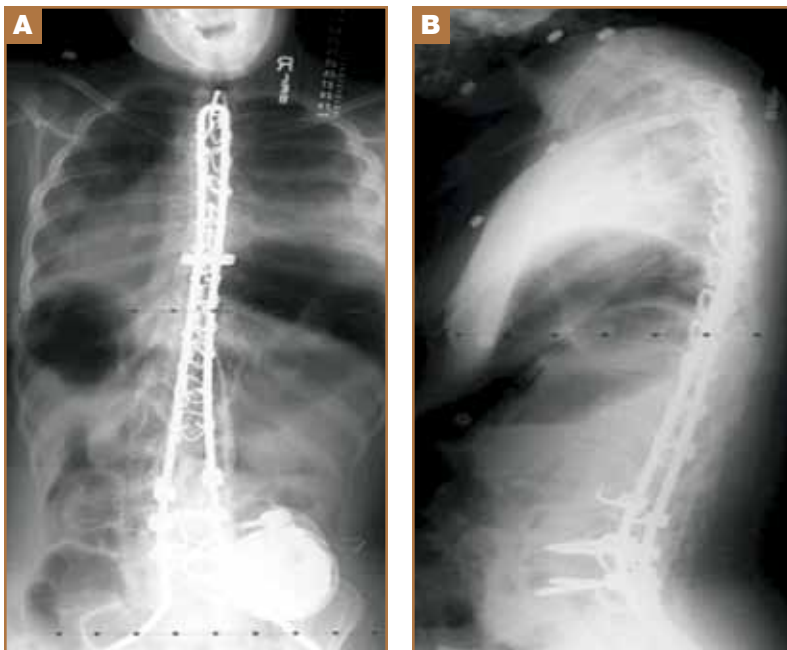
Patient's postoperative posteroanterior (A) and lateral (B) radiographs show posterior spinal fusion with use of Luque rod segmental instrumentation.
